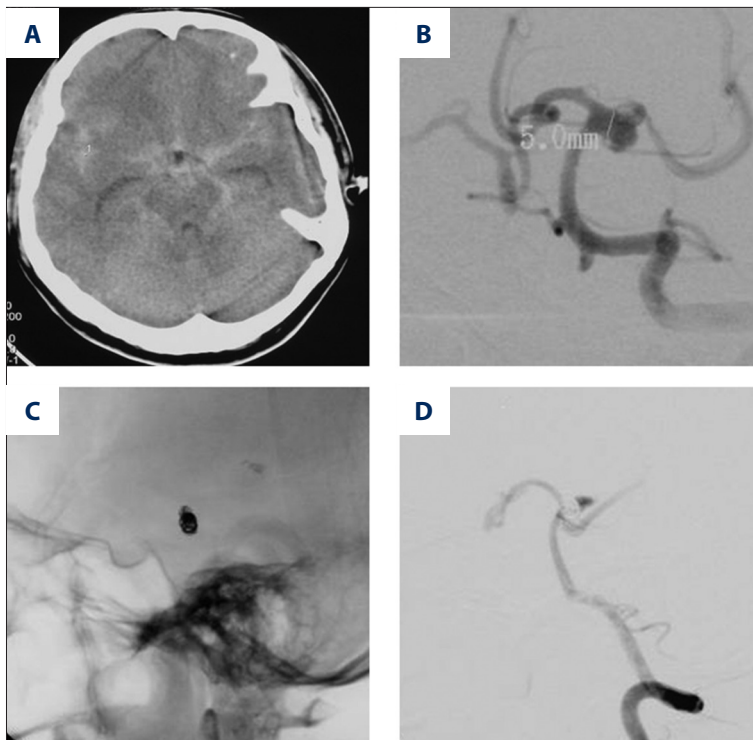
A 41-year-old male complaining of sudden-onset headache exhibited (A) SAH on head CT scan. Cerebral DSA (B) revealed a P1 RICABF involving the left posterior cerebral artery. The proximal true aneurysm cavity and the aneurysm neck (C) were compactly embolized. Immediate angiography (D) showed contrast media stagnation in the bleb of RICABF.
